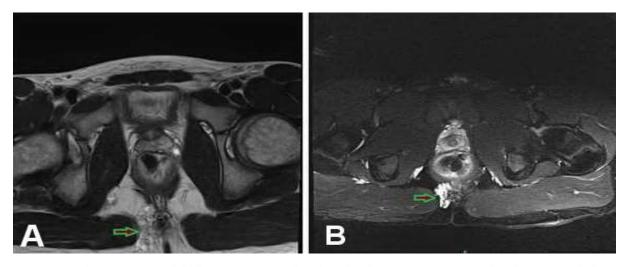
A) Peri-coccyx LM on initial MRI. B) Decreasing size of peri-coccyx LM on repeat imaging 13 months later.
